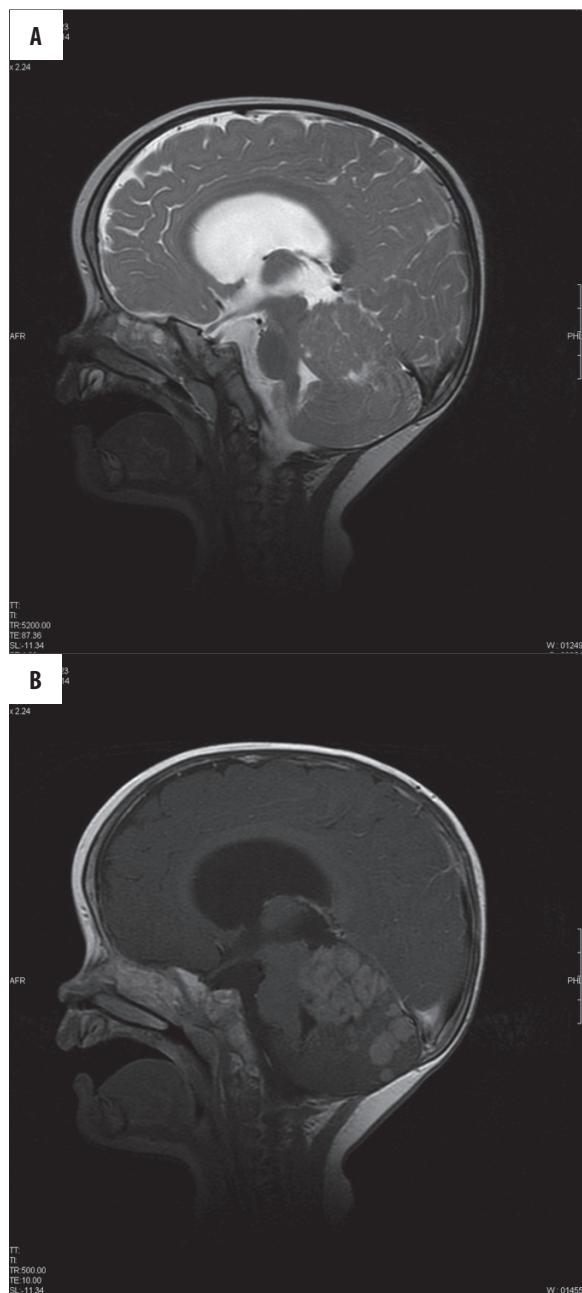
MRI. (A) Sagittal T2WI. Nodular lesions in the vermis, following signal intensity of the cortex, with gyral pattern. (B) Sagittal T1WI. Contrast enhancement of the mass after gadolinium administration.
